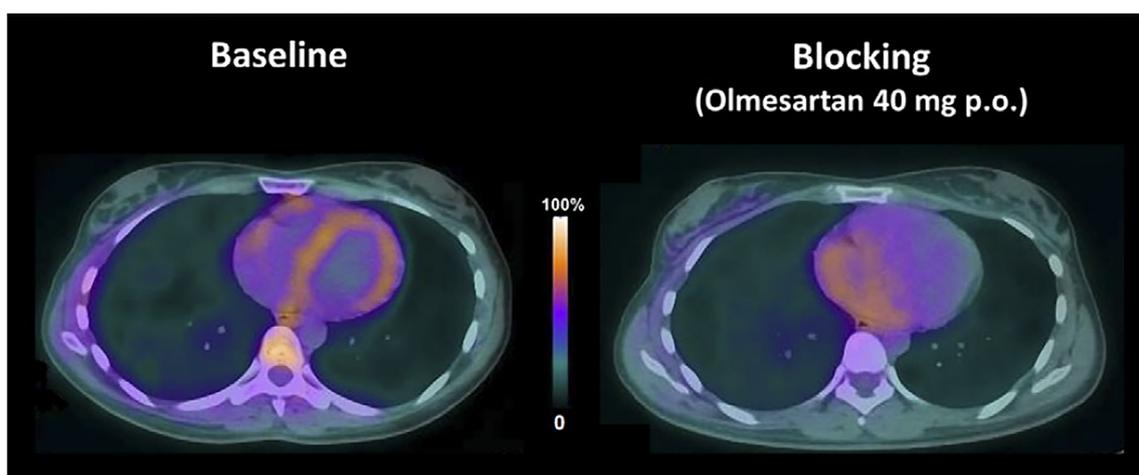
Myocardial AT1-R imaging with ^{11}C -KR31173 and PET/CT imaging. Baseline transaxial PET/CT images in the mid-ventricular myocardium demonstrate homogeneous uptake of ^{11}C -KR31173 in left-ventricular myocardium (left side). Repeat imaging 3 h after an oral (p.o.) dose of 40-mg olmesartan for specific blocking of AT1-R signifies
